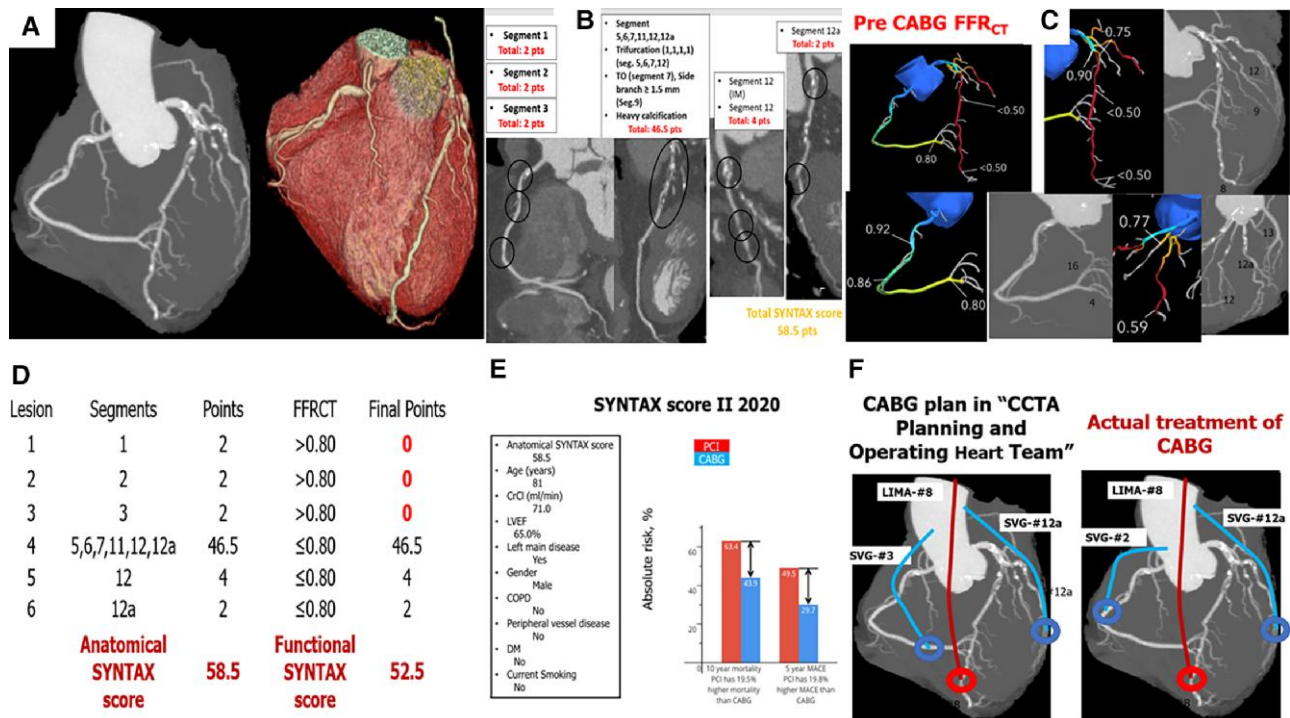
Example of a planning of coronary artery bypass graft procedure by coronary computed tomography angiography. A case of 81-year-old male with stable angina with three-vessel disease by coronary computed tomography angiography. The maximal intensity projection and volume rendering images in A show the extent of disease and allow identifying the distal bed of coronary arteries. (B) The coronary computed tomography angiography-derived anatomical Syntax Score and (C) the fractional flow reserve from coronary computed tomography angiography images. (D) The functional Syntax score (in particular the lesions on right coronary artery were derubricated from the score because of normal fractional flow reserve from coronary computed tomography angiography images). (E) The calculation of Syntax Score II has been assessed, which provides the Heart Team with a recommendation on the mode of revascularization (percutaneous coronary intervention or coronary artery bypass graft). (F) The planning of coronary artery bypass graft procedure based solely on coronary computed tomography angiography. In this case, although there is a normal fractional flow reserve from coronary computed tomography angiography images on right coronary artery, the surgeon decides to make a bypass also on right coronary artery.
